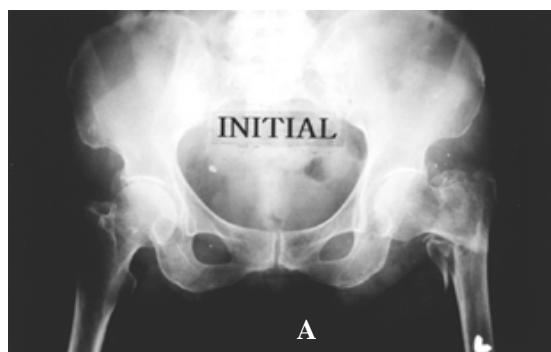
Serial radiographs of 72 year-old woman treated with a cemented bipolar endoprosthesis.
